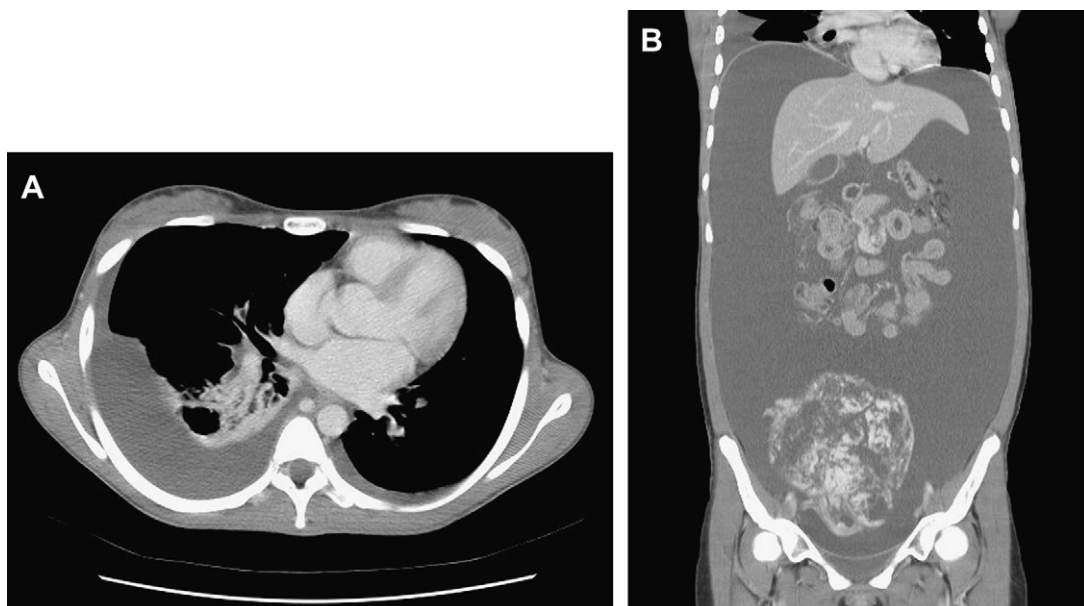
Right-sided pleural effusion with atelectasis in the right lower lung. (A) Contrast-enhanced computed tomography scan demonstrates a 15 cm \times 14 cm \times 10 cm rounded pelvic mass with a solid component and (B) hypodense areas accompanied by massive ascites.
